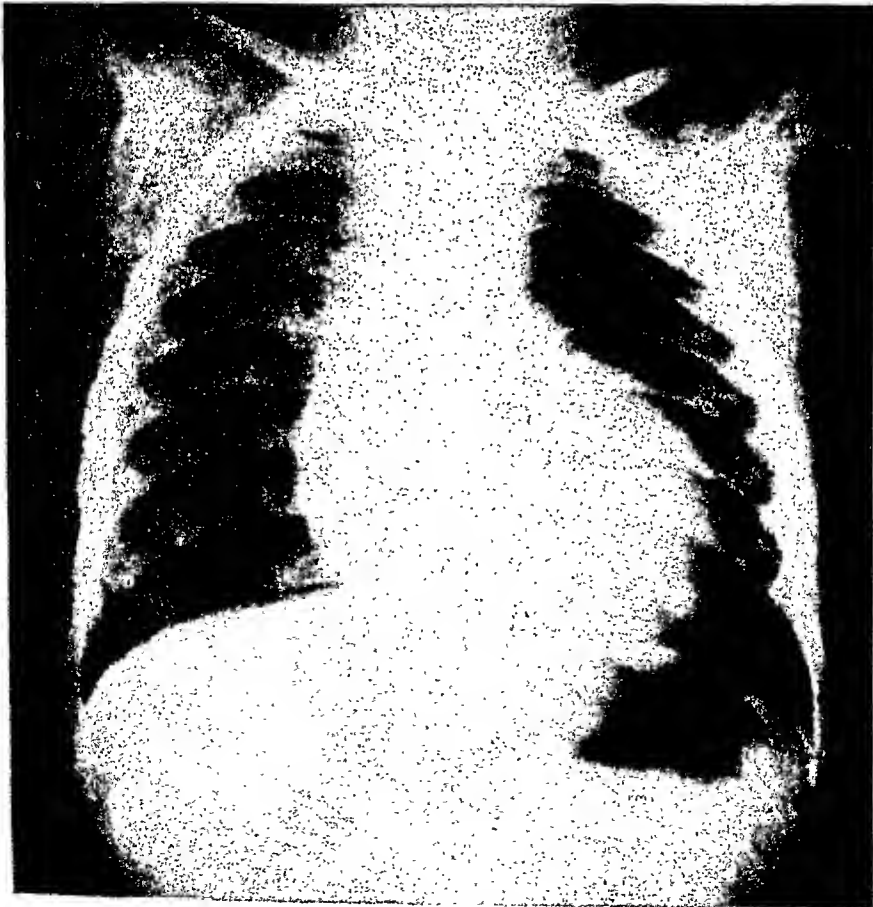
An ordinary x-ray film of a 4-year-old child with cor biloculare or cor triloculare biatriatum with a persistence of a single arterial trunk.
